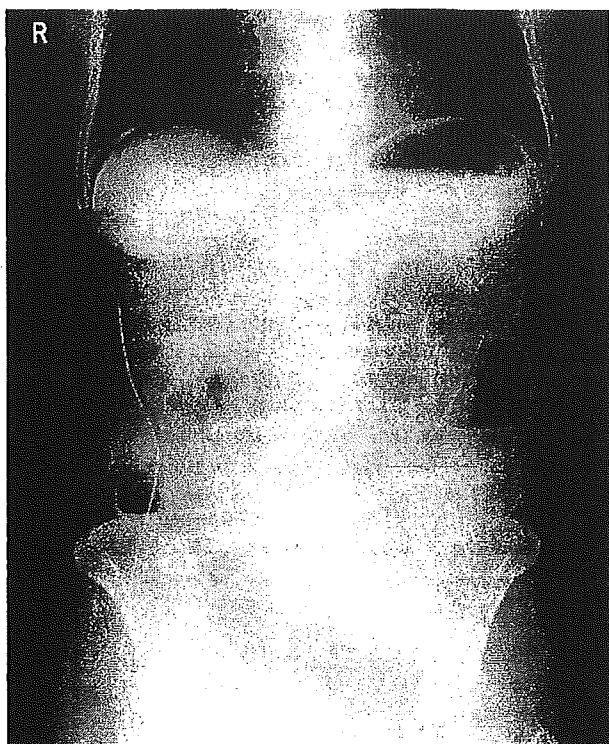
Plain abdominal x-ray. Air-fluid levels in the left upper quadrant.
